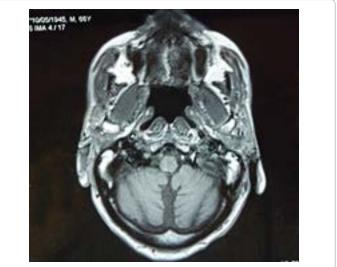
Axial cerebral MRI of the Patient (T, weighted): cerebellar atrophy.
